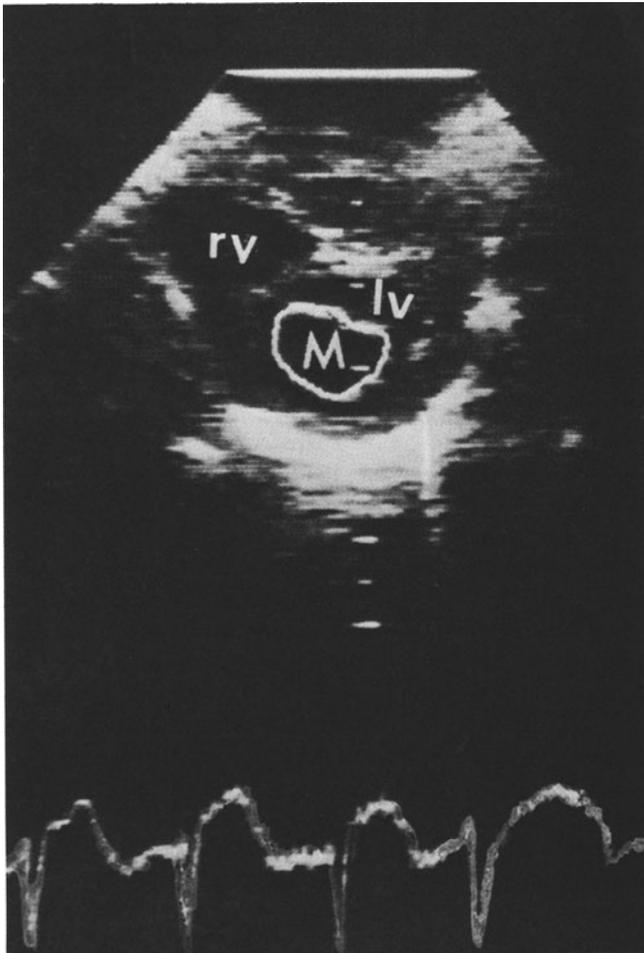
Two-dimensional short-axis echocardiogram at the level of the mitral leaflets tips, with microcomputer-assisted delineation of the mitral valve orifice in early diastole (*m*) for mitral valve area measurement (*rv*, right ventricle; *lv*, left ventricle).
